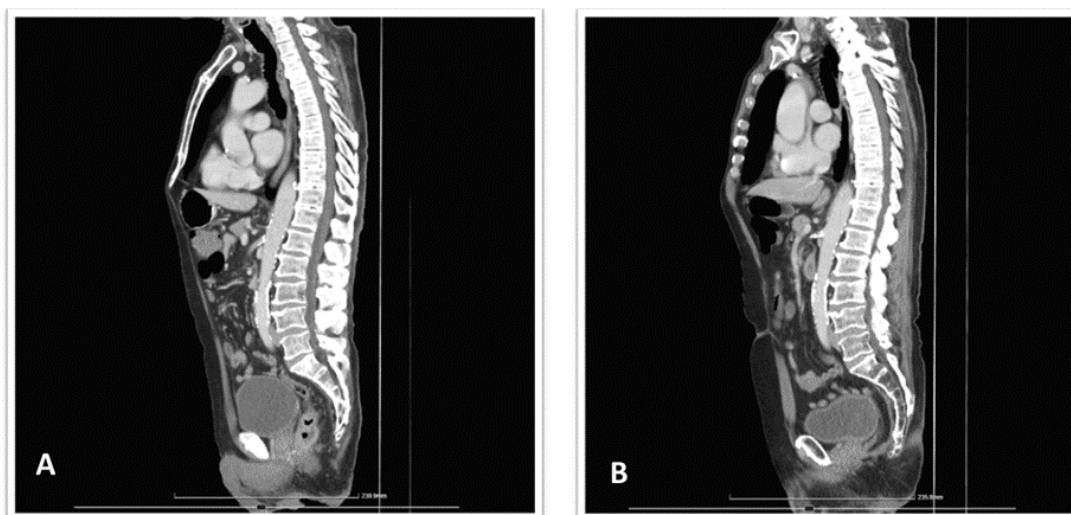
Computed Tomography at midsagittal plane. A – captured on 06.01.2020, showing a low rectal tumor obstructing the lumen and a gas-inflated colon. B – captured on 01.06.2021, showing no local recurrence of low rectal cancer at 6-months after neoadjuvant chemotherapy and abdominoperineal surgery
